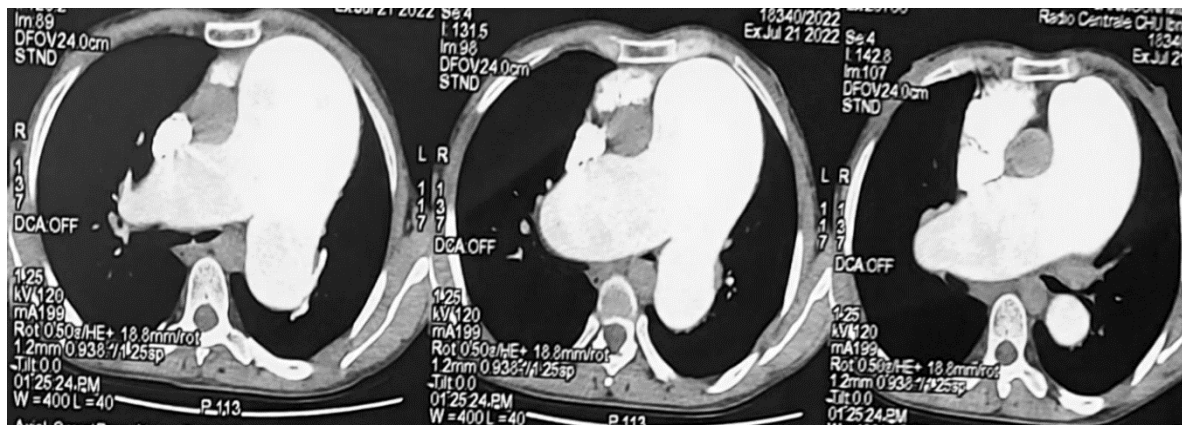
Chest CT showing aneurysmal dilatation of the trunk of the artery lung and its branches
